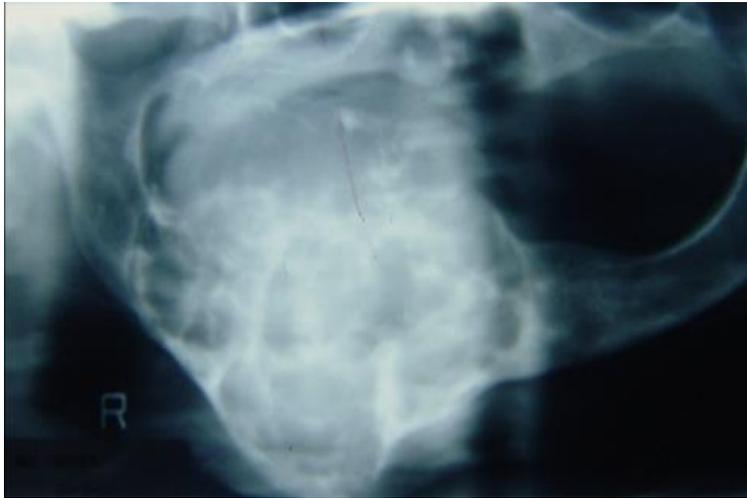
Lateral radiograph showing a radiopaque shadow compatible with osteosarcoma
